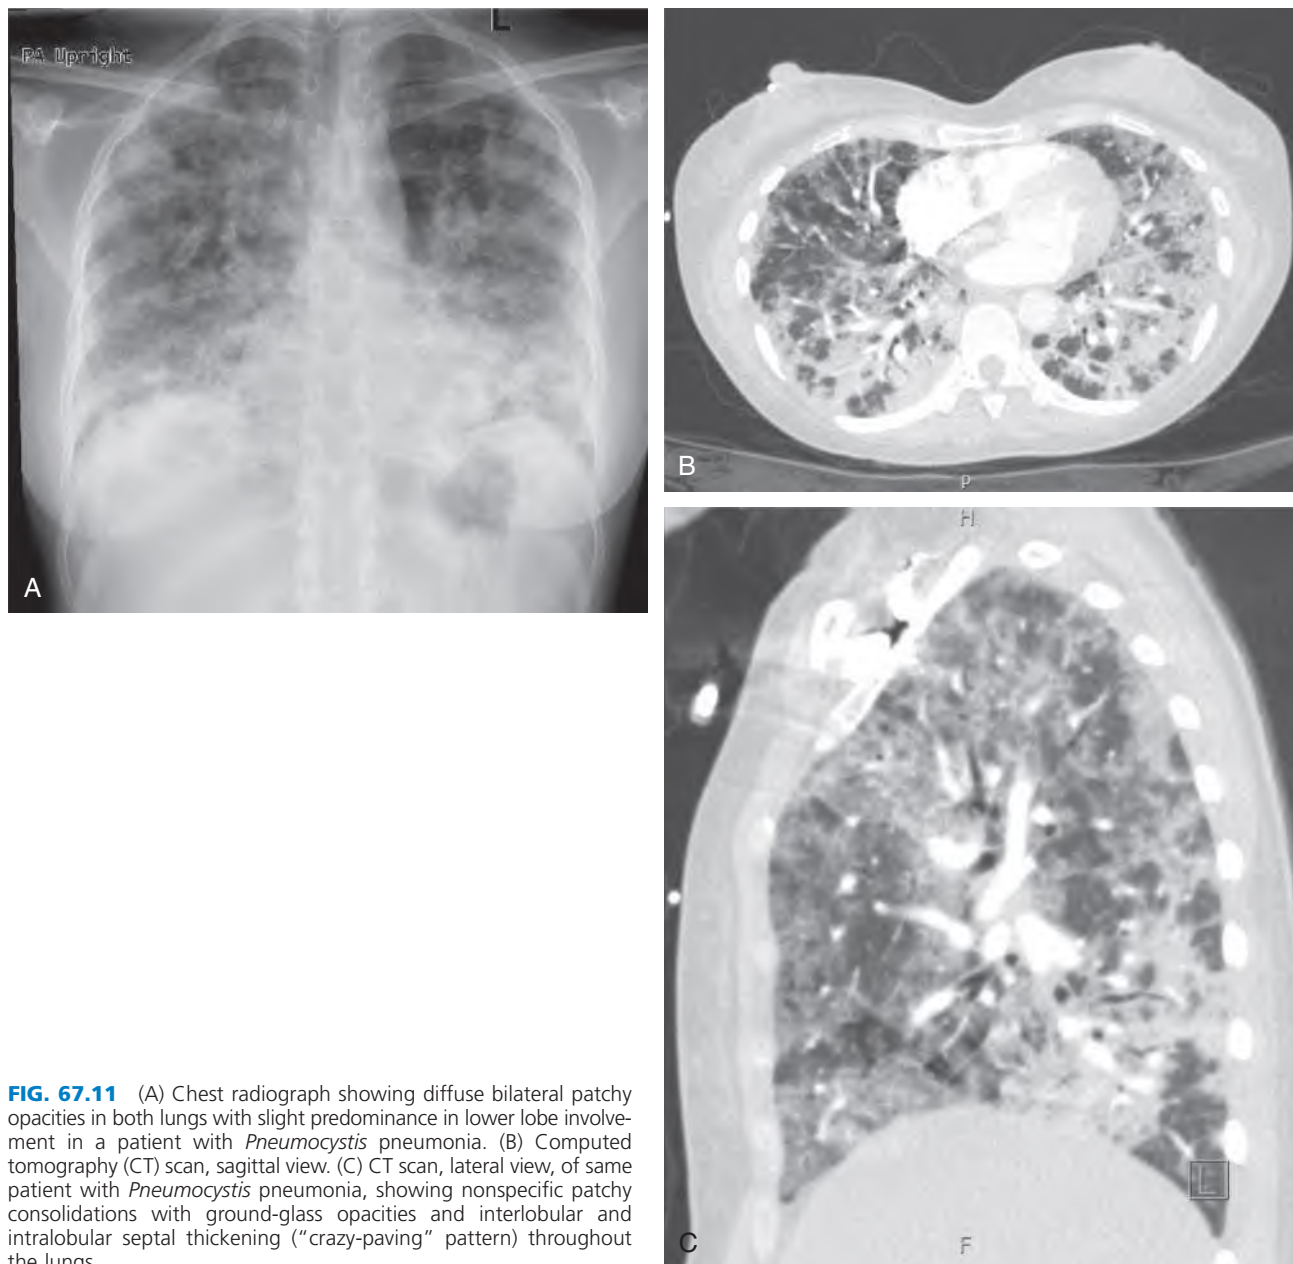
(A) Chest radiograph showing diffuse bilateral patchy opacities in both lungs with slight predominance in lower lobe involvement in a patient with *Pneumocystis* pneumonia. (B) Computed tomography (CT) scan, sagittal view. (C) CT scan, lateral view, of same patient with *Pneumocystis* pneumonia, showing nonspecific patchy consolidations with ground-glass opacities and interlobular and intralobular septal thickening (“crazy-paving” pattern) throughout the lungs.
